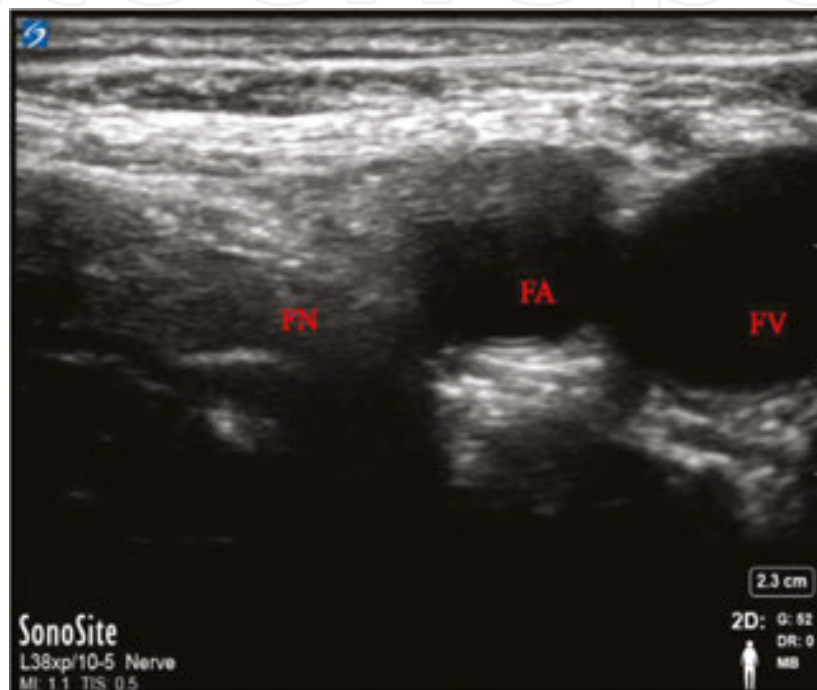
Ultrasound view of the femoral nerve. FA, femoral artery; FV, femoral vein; FN, femoral nerve.
